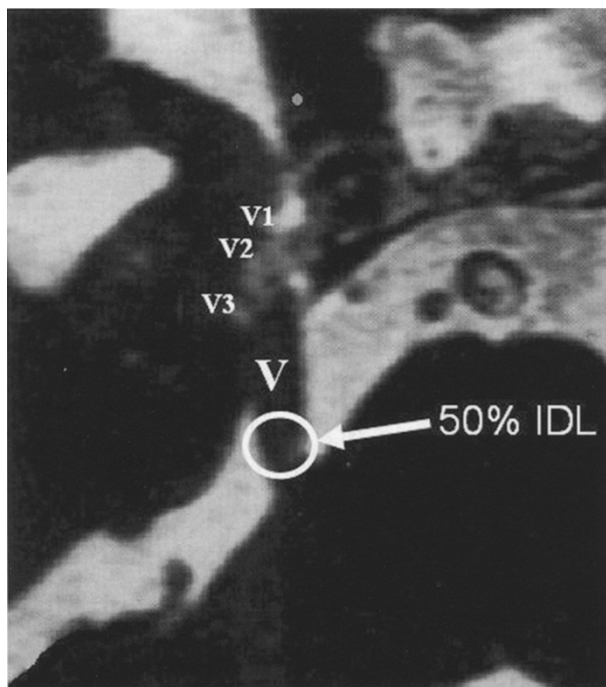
Visualization of the trigeminal complex with magnetic resonance imaging using constructive interference steady state (CISS). Notice the target location at the root entry zone. The 50% isodose line touches the brainstem as demonstrated by the arrow. The dose use is 90 Gy to the target point, not to the volume demonstrated. 45 Gy touches the surface of the brainstem
